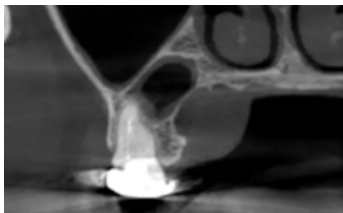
Coronal section of CBCT showing soft tissue enlargement
